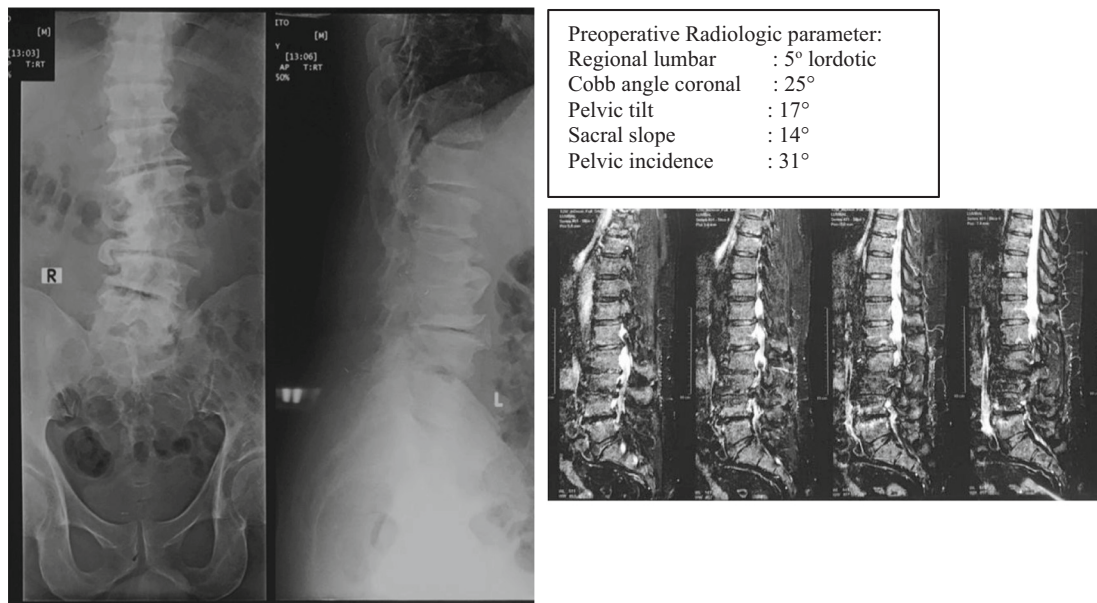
Case 7 initial radiograph presentation.
